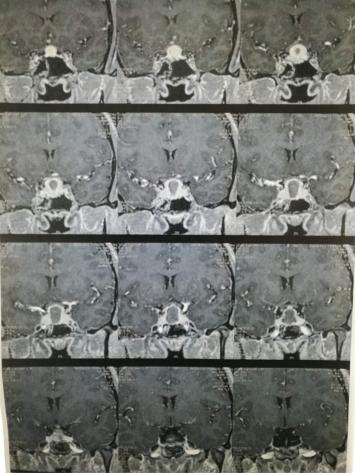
Pre operative MR images sagittal and coronal T1-weighted demonstrating an iso intense lesion in the pituitary fossa, with ring enhancement after contrast injection.
